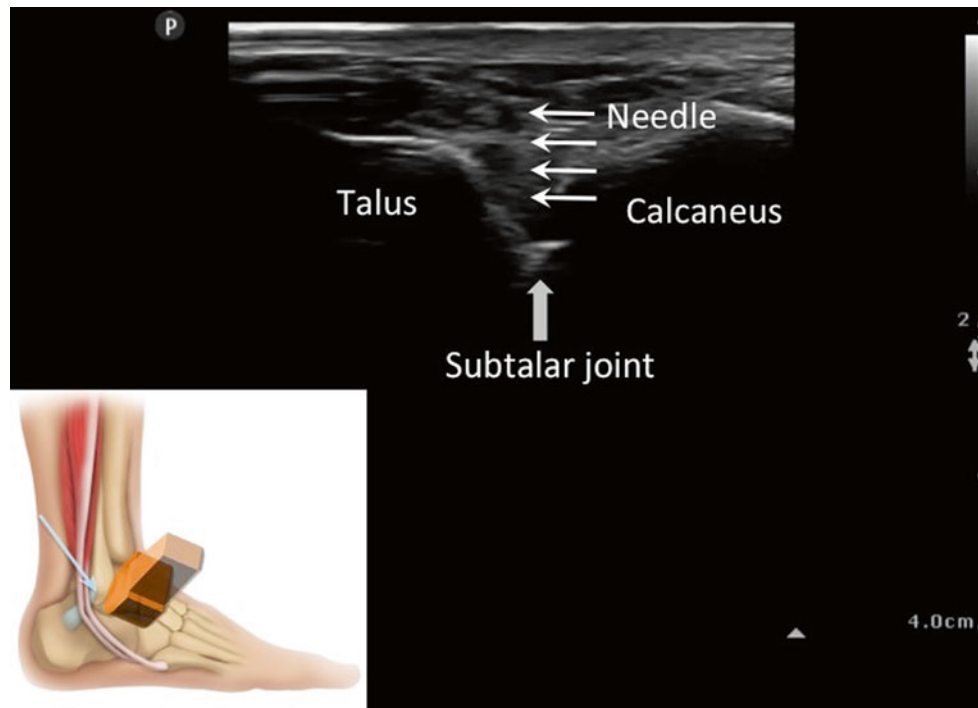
Sonogram shows out-of-plane needle insertion for subtalar joint. The insert shows the anatomy and the ultrasound probe position. The line arrows indicate the needle path (Reproduced with permission from Philip Peng Educational Series)
